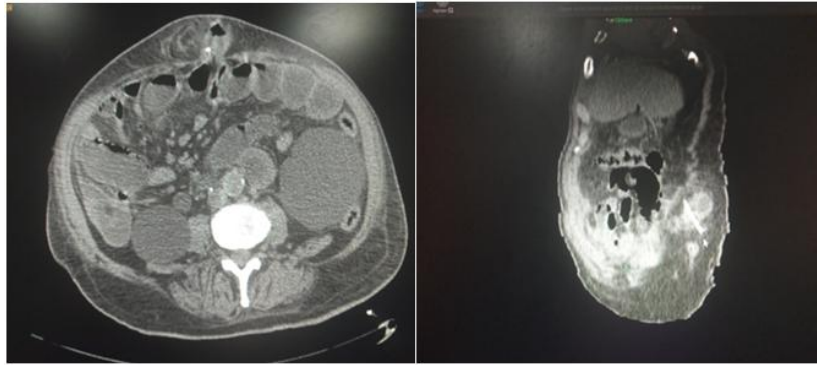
CT-scan images that shows hernia with the pneumoperitoneum
